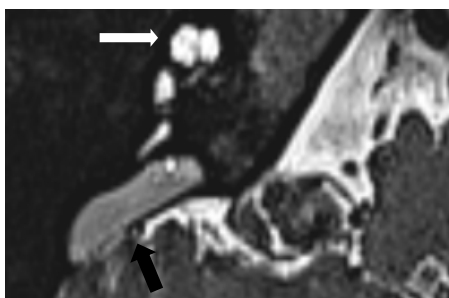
MRI axial cuts showing right EVA with IPH.
